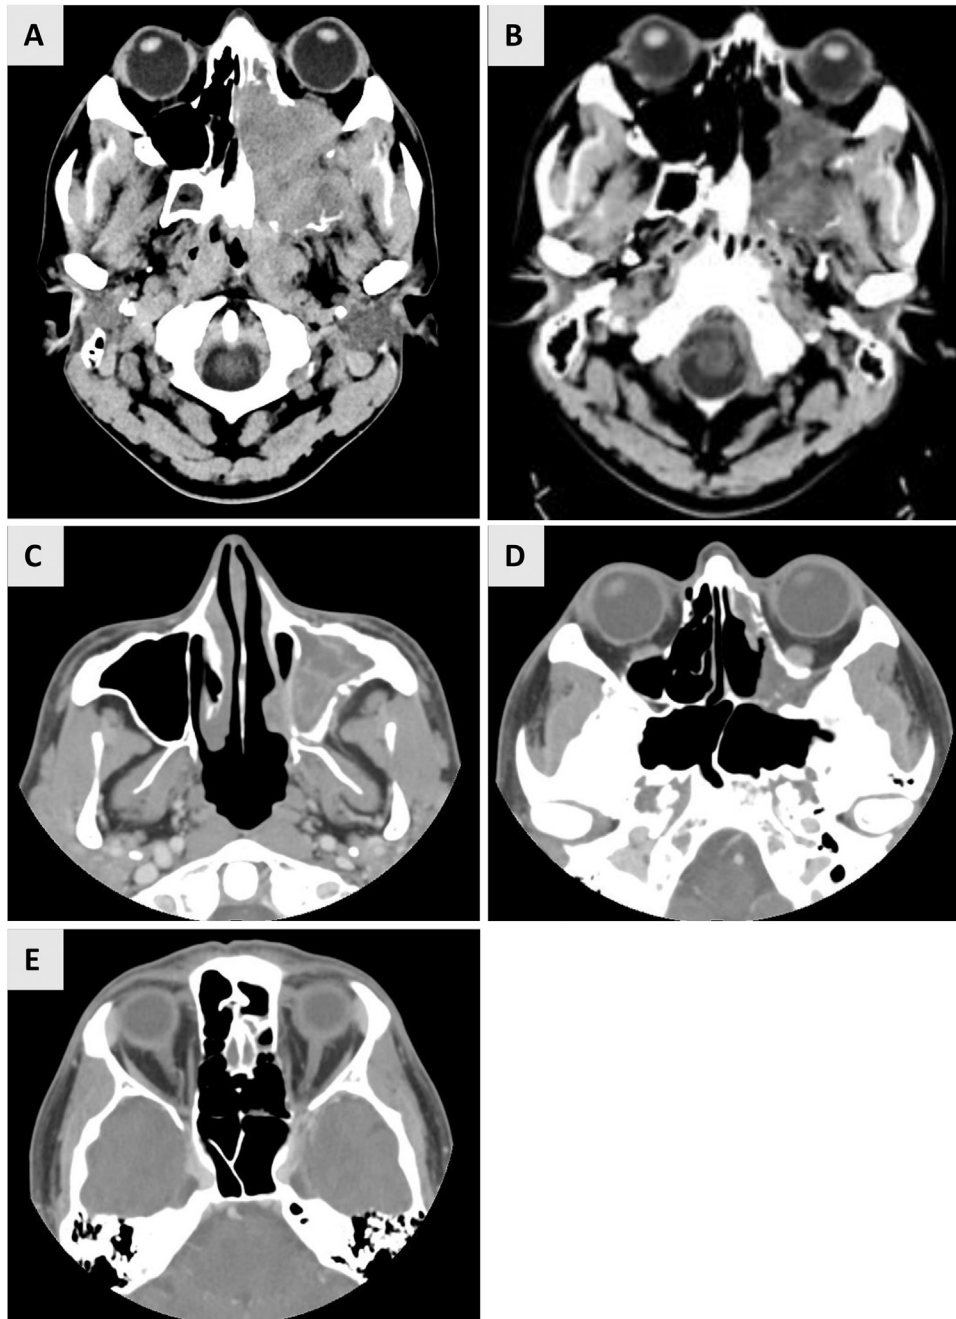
A series of axial noncontrast head/maxillary CT studies at different timeframes of treatment. (A) On admission, there is 6.5 × 4.2 cm soft tissue mass centered in the left paranasal ethmoid/sphenoid and maxillary sinuses with erosive changes, cortical breakthrough, and invasion of the left retrobulbar orbit and right ethmoid sinus. There is left extraocular muscle displacement and retrobulbar narrowing. (B) After 1 cycle of chemotherapy, CT head shows notable reduction in the size of the mass. There is no involvement of the right ethmoid sinus and less involvement of the left sphenoid sinus and orbital cavity. (C-E) CT maxillary post fifth chemotherapy cycle revealed a significant reduction in the size of the mass. The mass continues to involve the left maxillary and ethmoid sinuses. No involvement of the left sphenoid sinus, orbit sinus, or optic nerve was noted in image.
